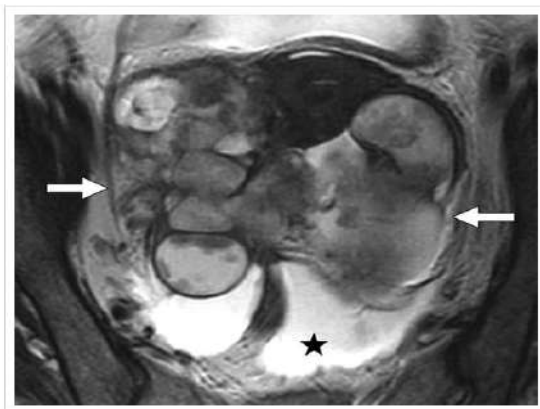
An MRI scan of a woman with Serous adenocarcinoma, the malignant masses are shown with arrows, the star represents ascites [4].
